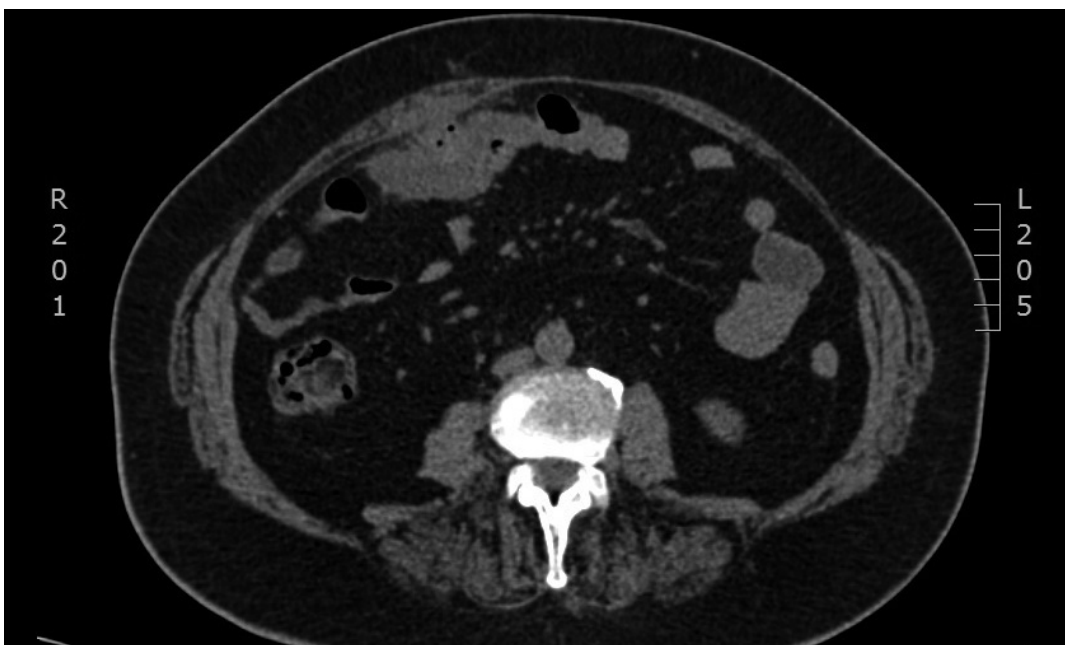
CT image of perforation.
